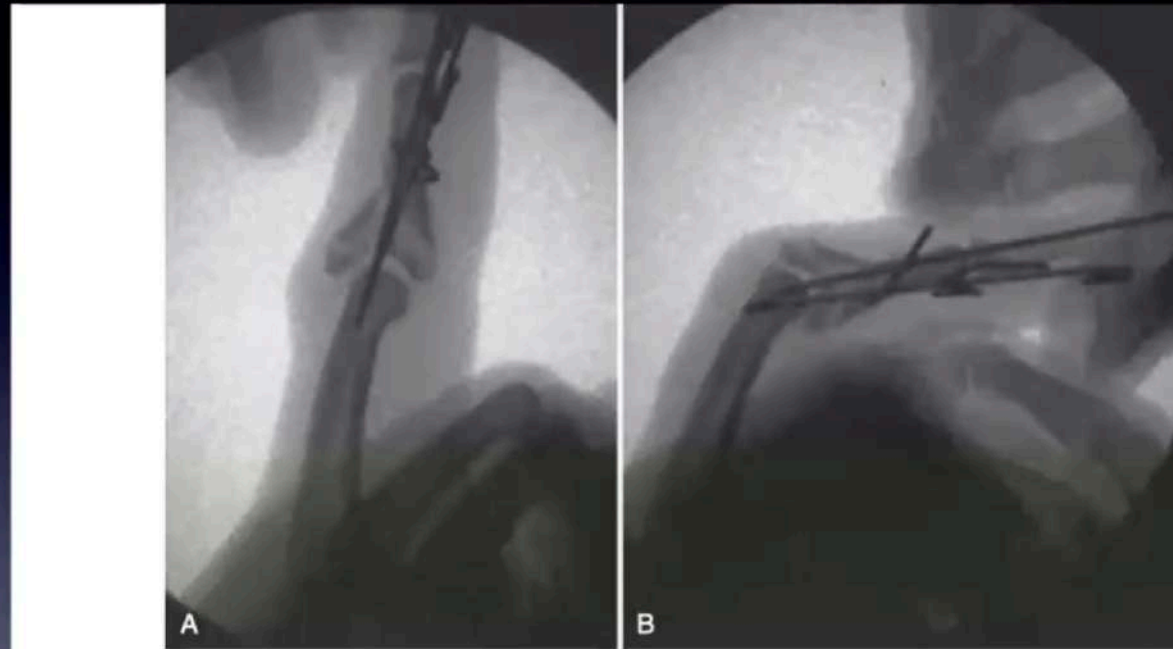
Full extension is typically the most unstable position. A, Lateral radiograph shows some overall widening at joint, but no subluxation or secondary incongruity. B, Lateral view with joint flexed also shows congruity.
